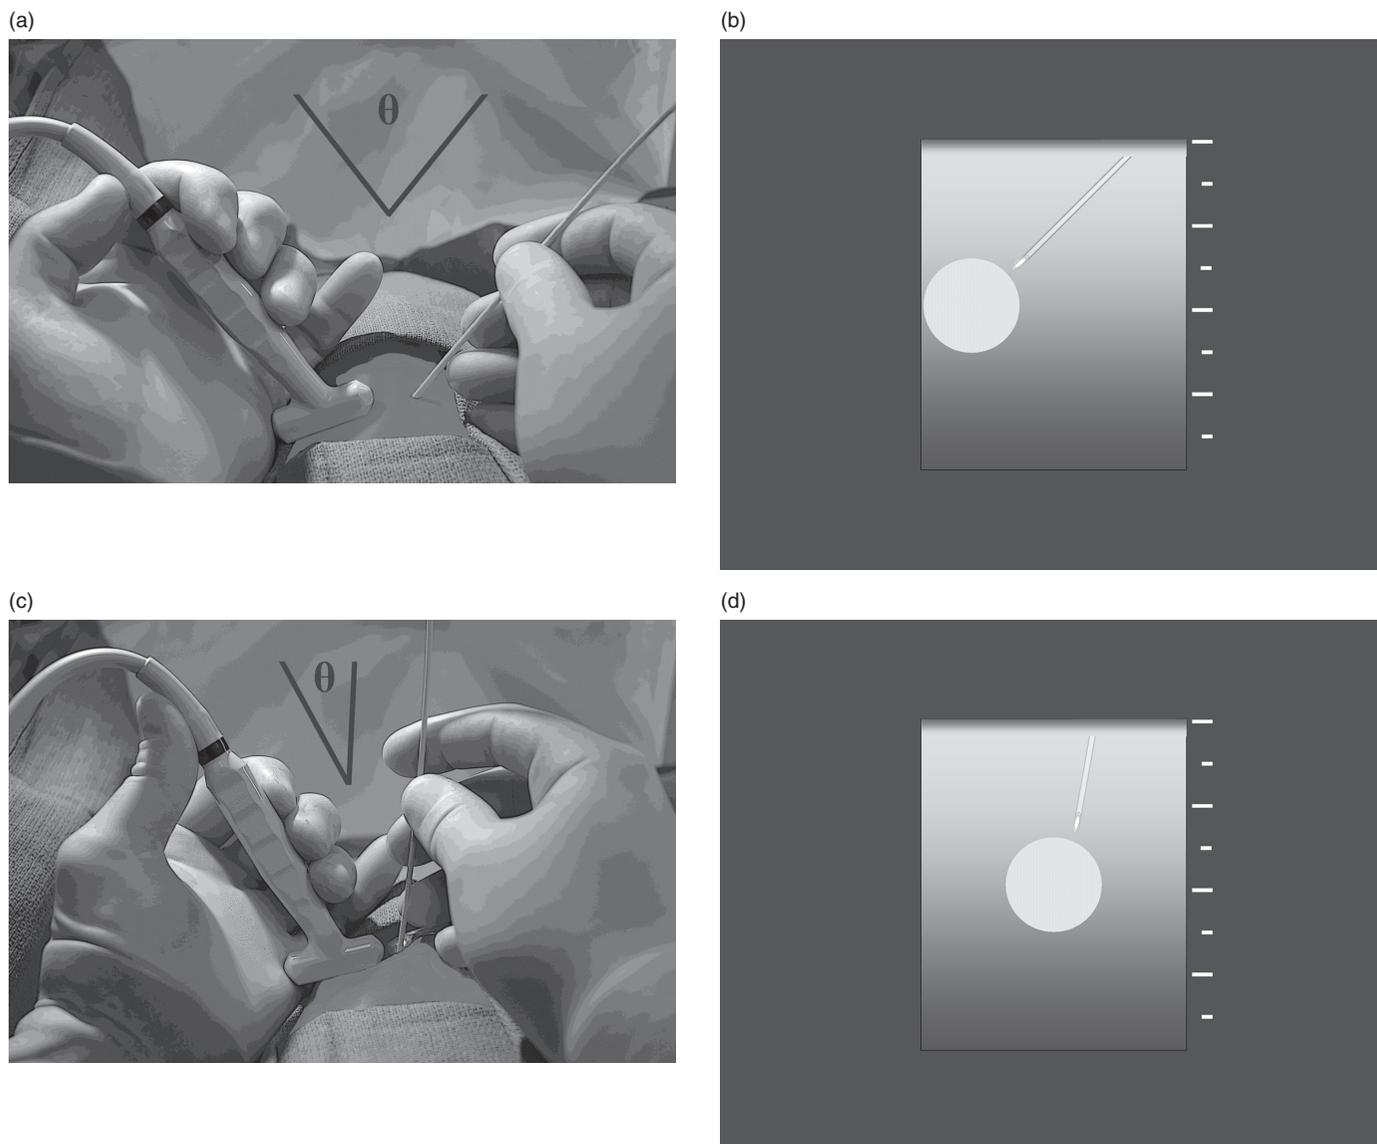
(a) Resting some part of each hand against the body surface reduces fatigue and unwanted motion during ultrasound-guided needle access. Obtaining a wide angle (θ) between the ultrasound transducer and the needle, by entering the skin some distance apart from the transducer, will significantly improve conspicuity of the needle. (b) The wide angle between the needle and the transducer and eccentric location of the lesion within the imaging field allows earlier and more conspicuous visualization of the needle shaft and tip in plane with the target lesion, increasing the opportunity for a successful outcome. (c) A narrow angle (θ) between the needle and transducer, often created by moving the needle too close to the transducer, may severely impair visualization. (d) With an acute angle between the needle and the transducer, and with the target centered in the imaging field, the needle is visualized poorly and over only a short part of its path. Partial visualization of the needle shaft, motion artifact, and less careful management of the tip location contribute to a higher likelihood of adverse outcomes. (e) When operating at a curved body surface, a needle entry point well away from the transducer allows an optimal (parallel) relationship between the needle and the transducer face. (f) Achieving the ideal parallel relationship between the transducer face and the needle shaft optimizes conspicuity of the needle, including the tip (due to “comet-tail” or “ring-down” artifact) and the entire length of the shaft (with “reverberation artifact”). Again, locating the target eccentrically in the imaging field allows visualization of the greatest possible length of the needle, including tip and shaft, in plane with the target lesion.
